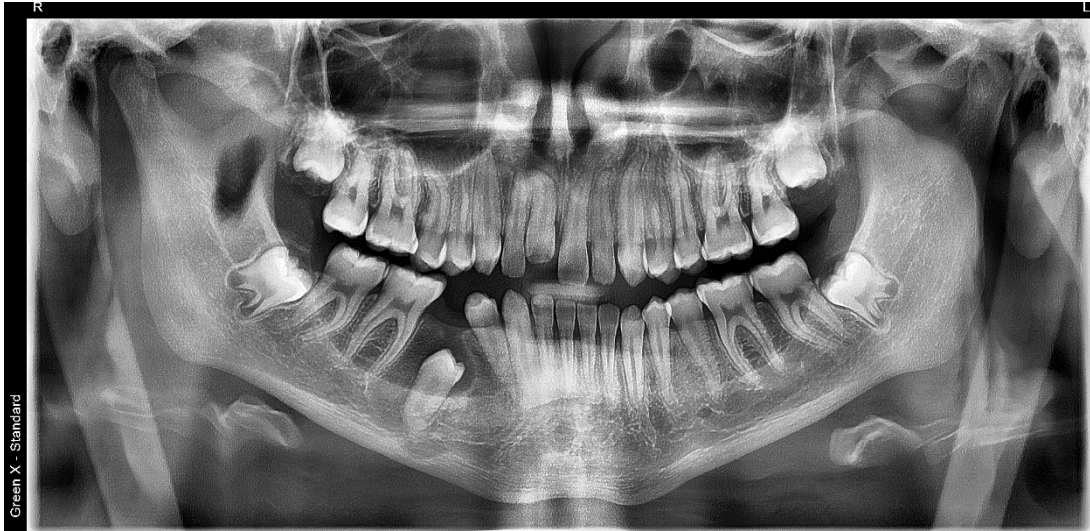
panoramic x-rays after 12 months
